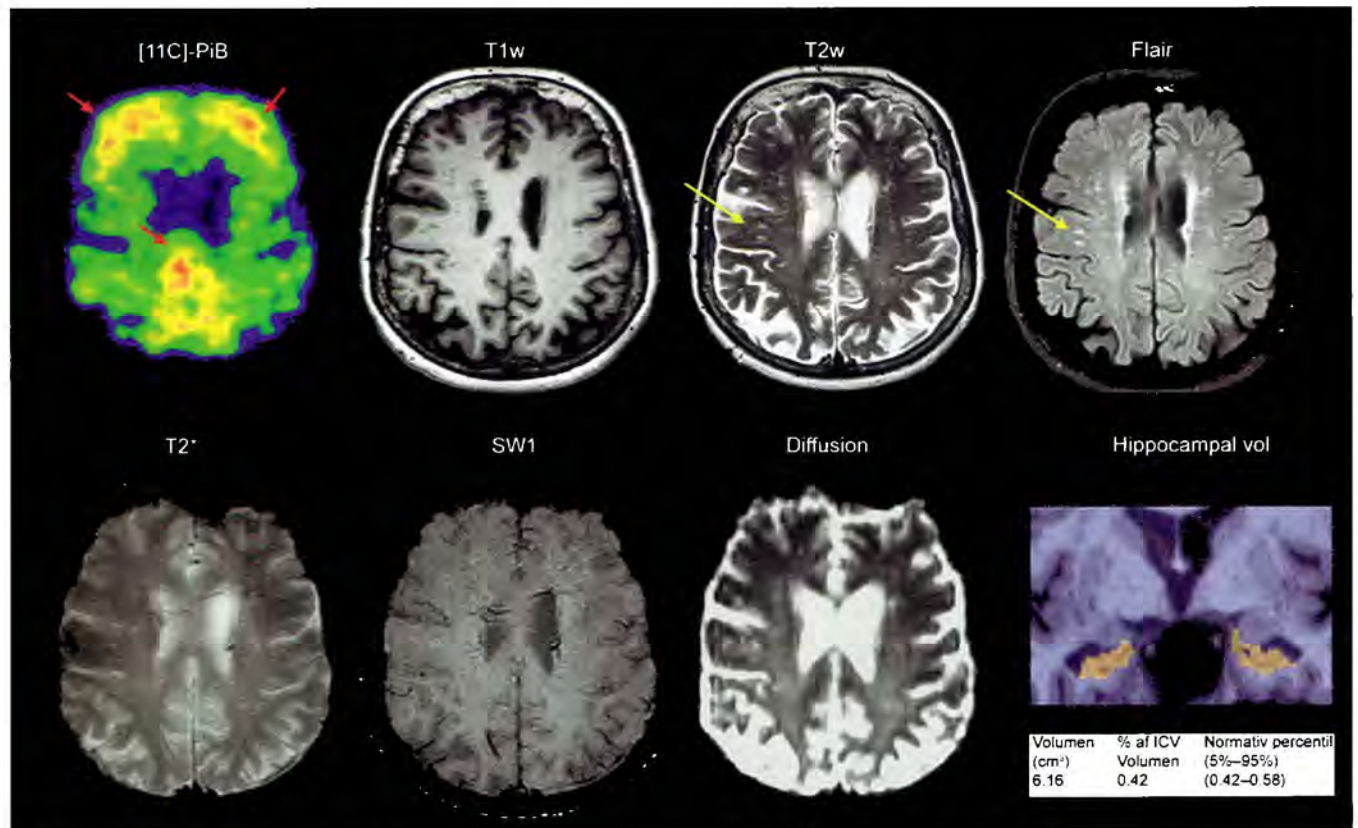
11C-Pittsburgh compound B (PiB) PET-MRI.
